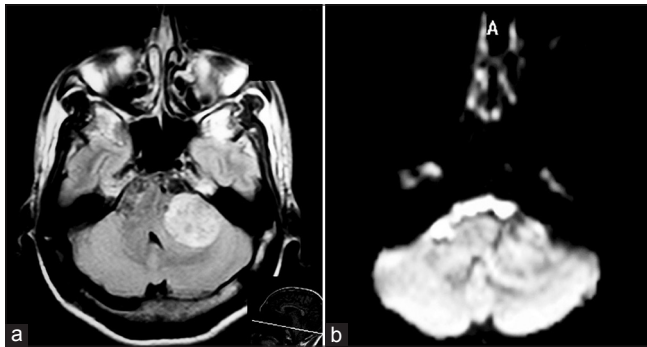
(a) FLAIR image with partial inversion of the epidermoid. (b) Diffusion weighted images showing restricted diffusion in the epidermoid
